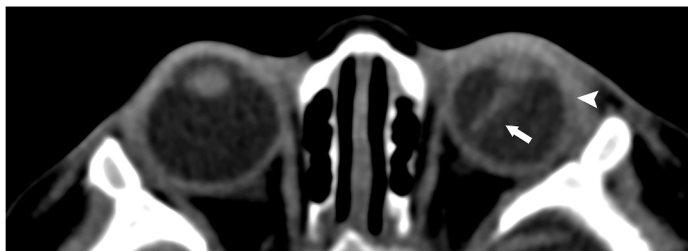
Unenhanced axial CT orbits shows cone-shaped retrolental soft tissue along the expected Cloquet canal (white arrow) and mild left microphthalmia (arrowhead), findings consistent with persistent fetal vasculature.
